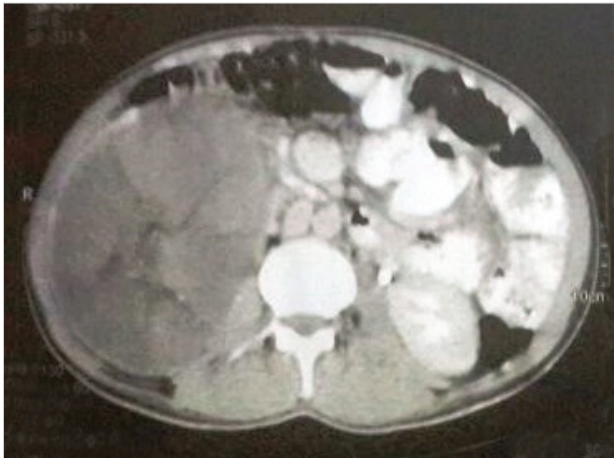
Case 2, right adrenal gland mass on computed tomography
